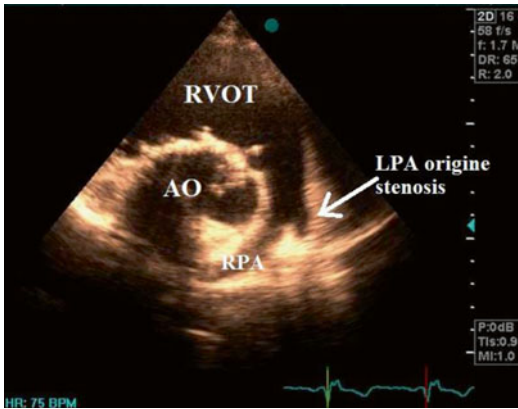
Left PA origin stenosis detected in 2D echocardiography which should be confirmed by CFI and Doppler study. Echocardiography is useful in making the diagnosis of proximal stenosis of PA branches and also excluding the related lesions. *Ao* aorta, *RVOT* right ventricular outflow tract, *RPA* right pulmonary artery
